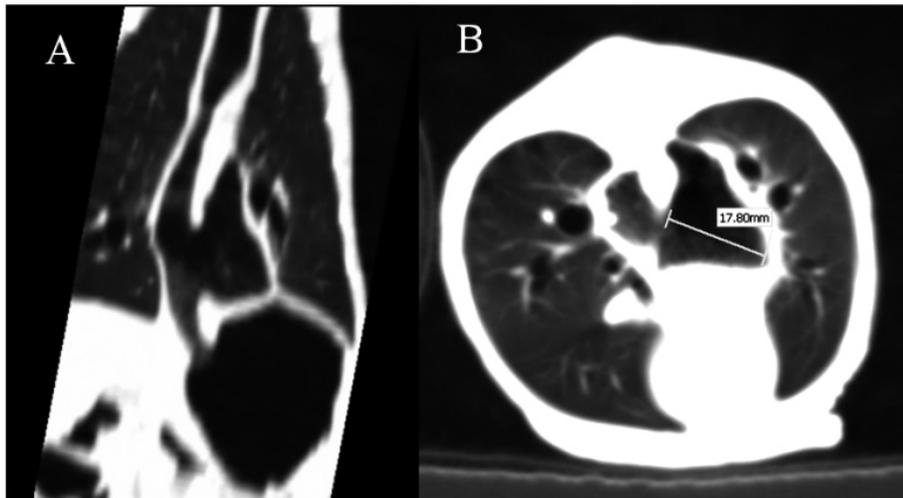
(A) Two-dimensional computed tomography dorsal image of esophageal diverticula. (B) Two-dimensional computed tomography transverse image, lung window, post contrast. Maximum width of the diverticula is 17.80 mm. There was no distinct evidence of fistula, adhesion, foreign body or stricture.
